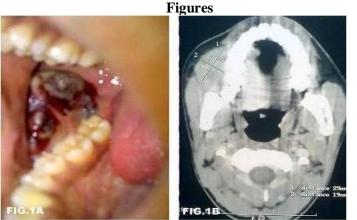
1A. Clinical photograph of the lesion. 1B. CT scan showing the tumor. (29 mm. x 19 mm.).
